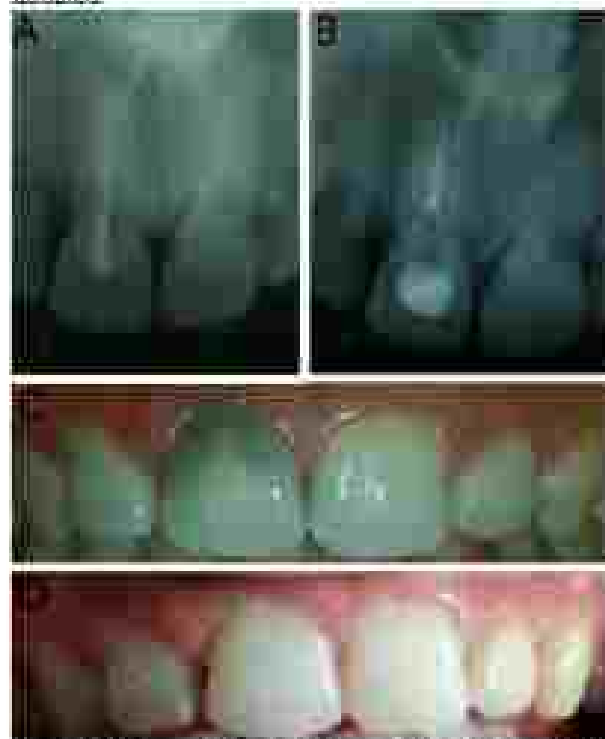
(A) Preoperative radiograph of tooth #11 (B) Successful re-treatment of tooth #11 (C) Preoperative photograph of #11 with black discoloration in the cervical third area (D) Post walking bleaching treatment photograph of #11 depicting a harmonious colour shade.
